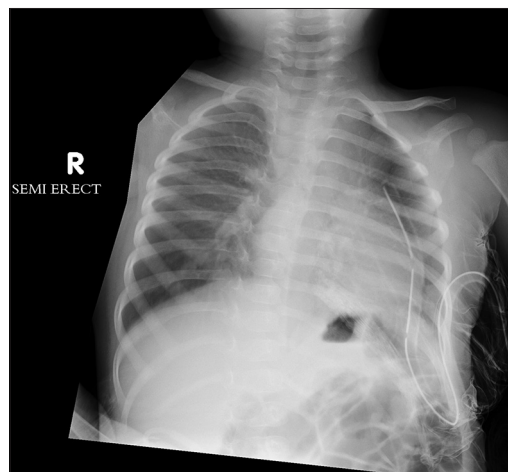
Post-operative chest X-ray image of the same child who underwent thoracoscopic repair for congenital diaphragmatic hernia and the contents of hernia were identified as intestinal loops, spleen and left kidney. The image shows an intercostal drain *in situ*, right apical lung field to be clear and presence of fundic gas bubble below the diaphragm confirming stomach to be normally placed
